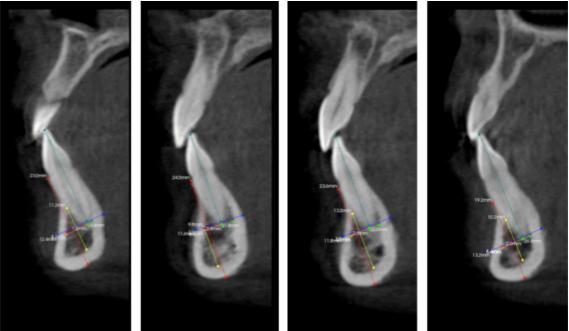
CBCT sagittal sections from patient 4 Incisors 32, 31, 41 and 42.
